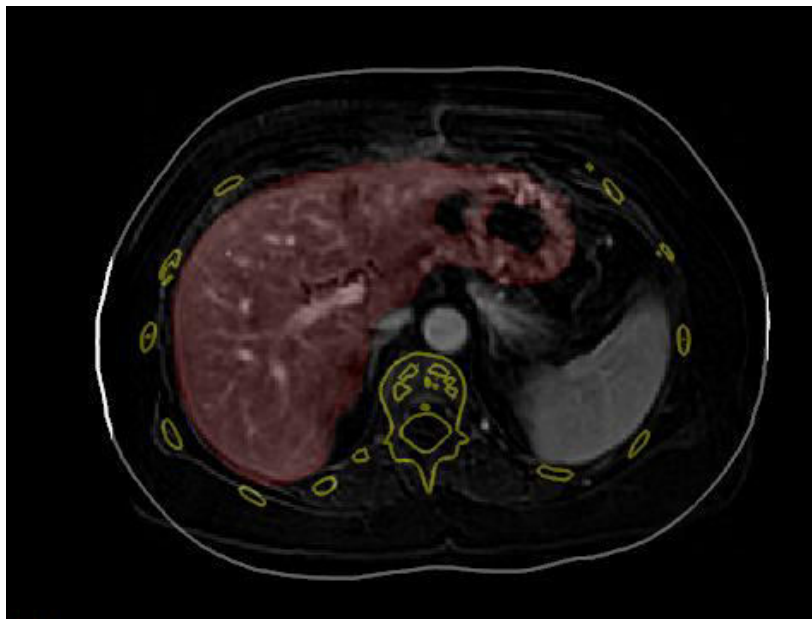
Ribs in yellow and skin in white registered on MRI image of the patient. A segmented part of the liver also can be seen in red.
